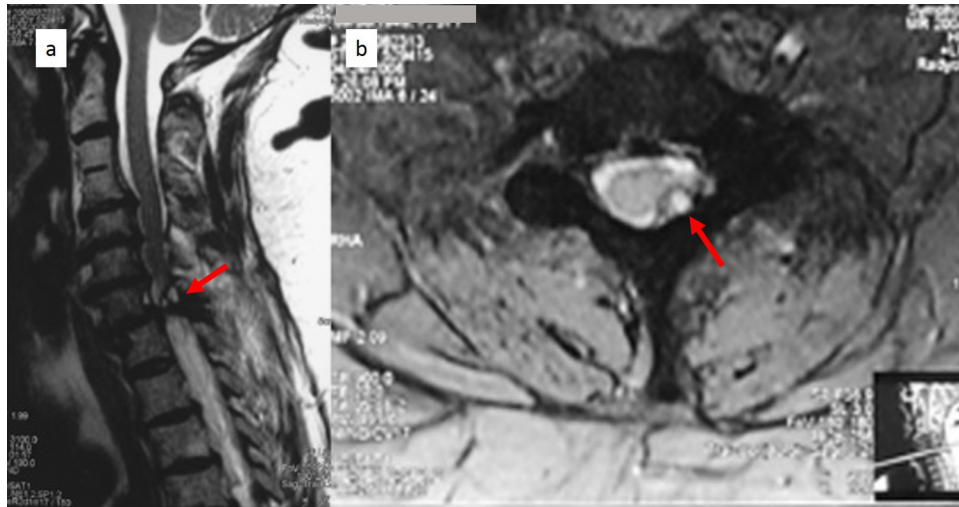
(a) T2 weighted sagittal MRI shows C2–C3 congenital fusion, C7–T1 spondylolisthesis and C7–T1 synovial cyst (arrow) and (b) T2 weighted axial MRI shows C7–T1 left sided synovial cyst (arrow).
